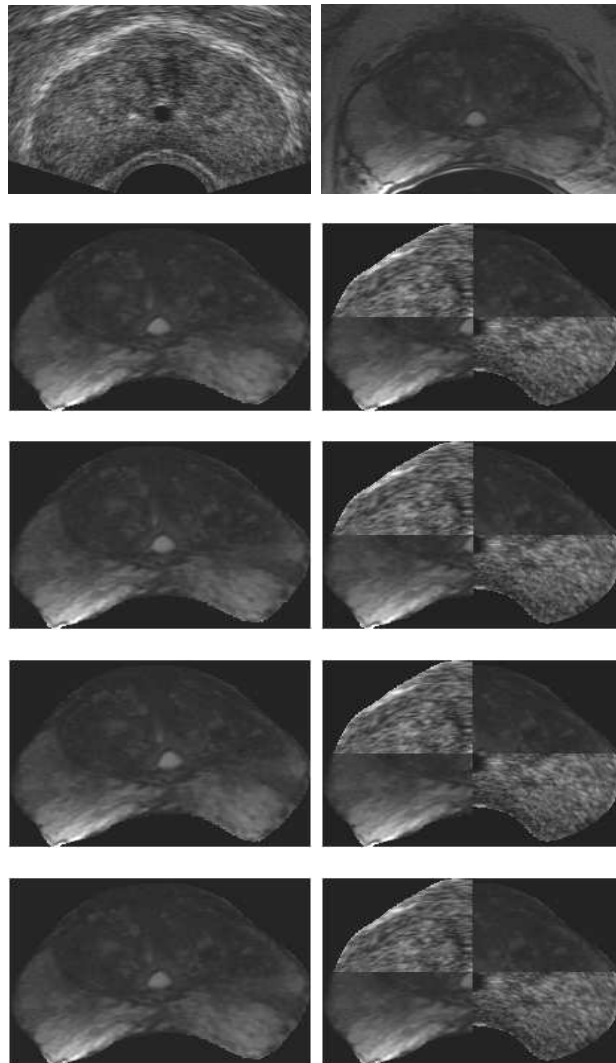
Deformation of the prostate gland with different sets of control points for Patient 6. Row 1 shows the TRUS and the MR images, row 2, 3 and 4 show the qualitative results of methods M1, M2 and M3 respectively and row 5 shows the results with the proposed optimum set of control points.
